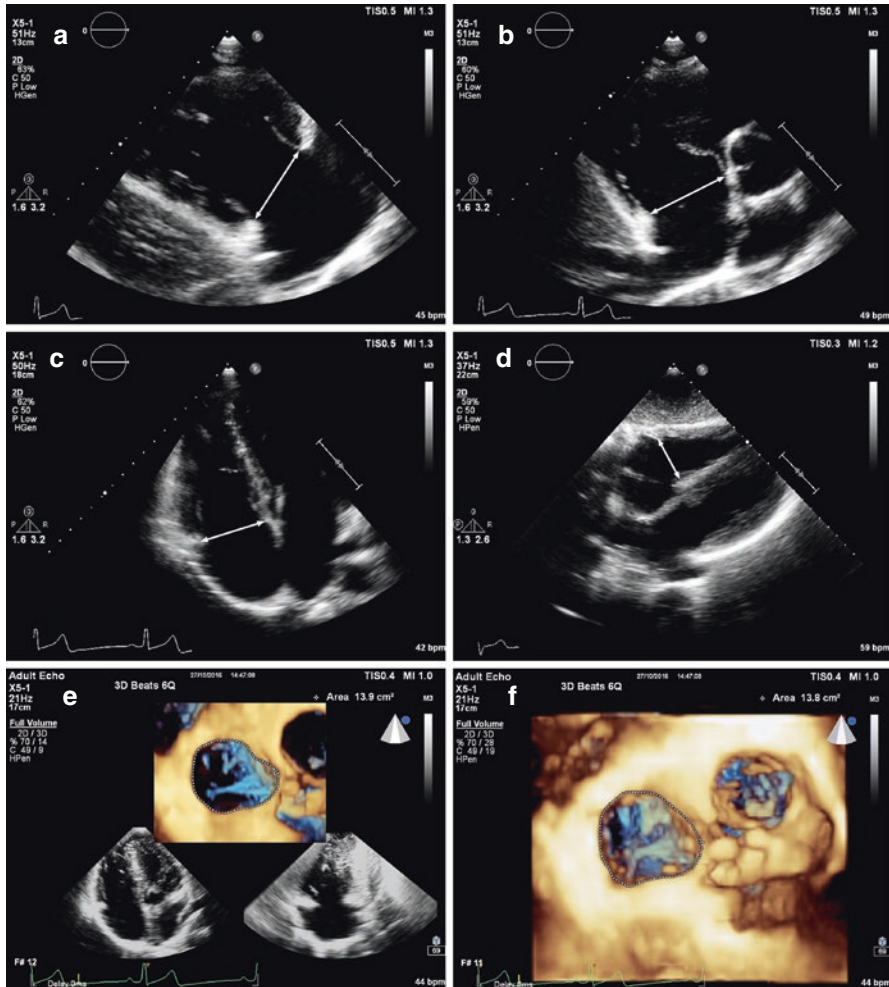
Displays end-diastolic tricuspid annulus (TA) measurements on 2D-TTE in the RV inflow long-axis view (a), short-axis view at the aortic valve level (b), apical four-chamber (c) and subcostal long-axis view (d). Image (e) display a multiplane area and image (f) details direct area measurement on the 3D
